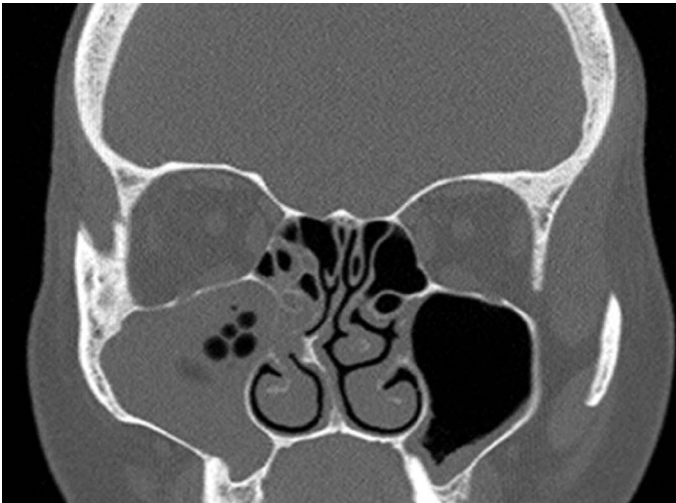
CT scan of sinuses in frontal projection. Visible chronic inflammatory process covering the right maxillary sinus with centrally visible mycelium. Nasal septum deviated ipsilaterally.
